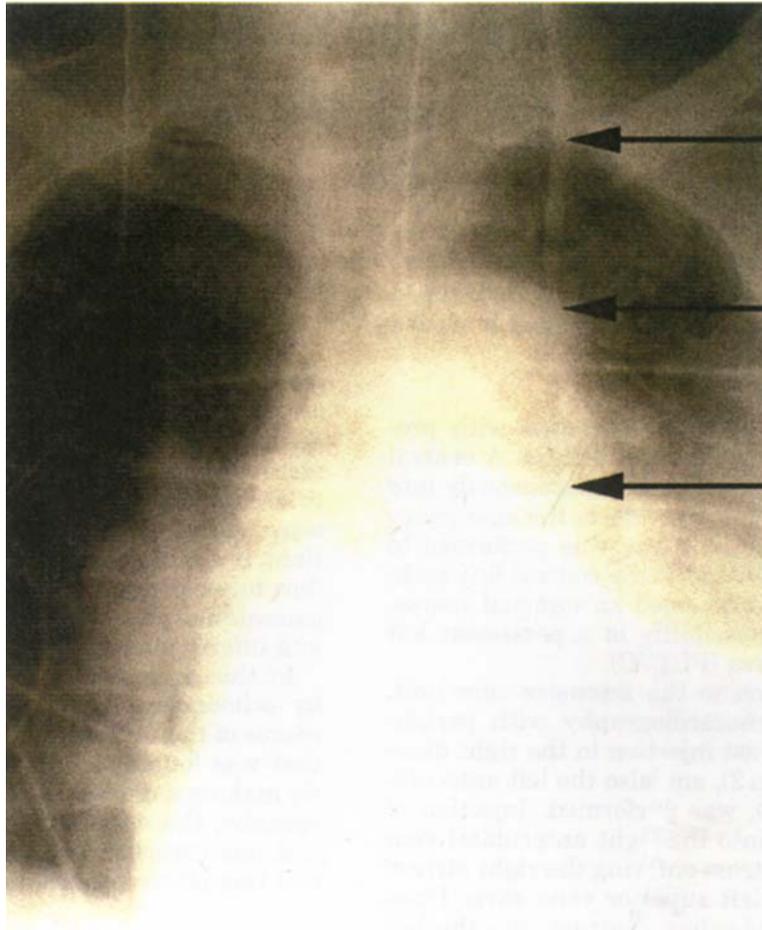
Portable AP chest X-ray after insertion of a left internal jugular vein central line catheter. Arrows point to the unusual course of the catheter within a persistent left superior vena cava.
